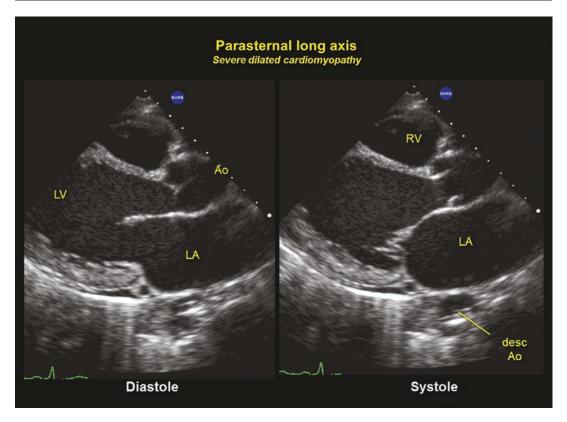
Parasternal two-dimensional echocardiographic images in diastole and systole from a patient with a dilated cardiomyopathy, including a dilated left atrium. Note the mitral-aortic continuity. *desc Ao* descending aorta
